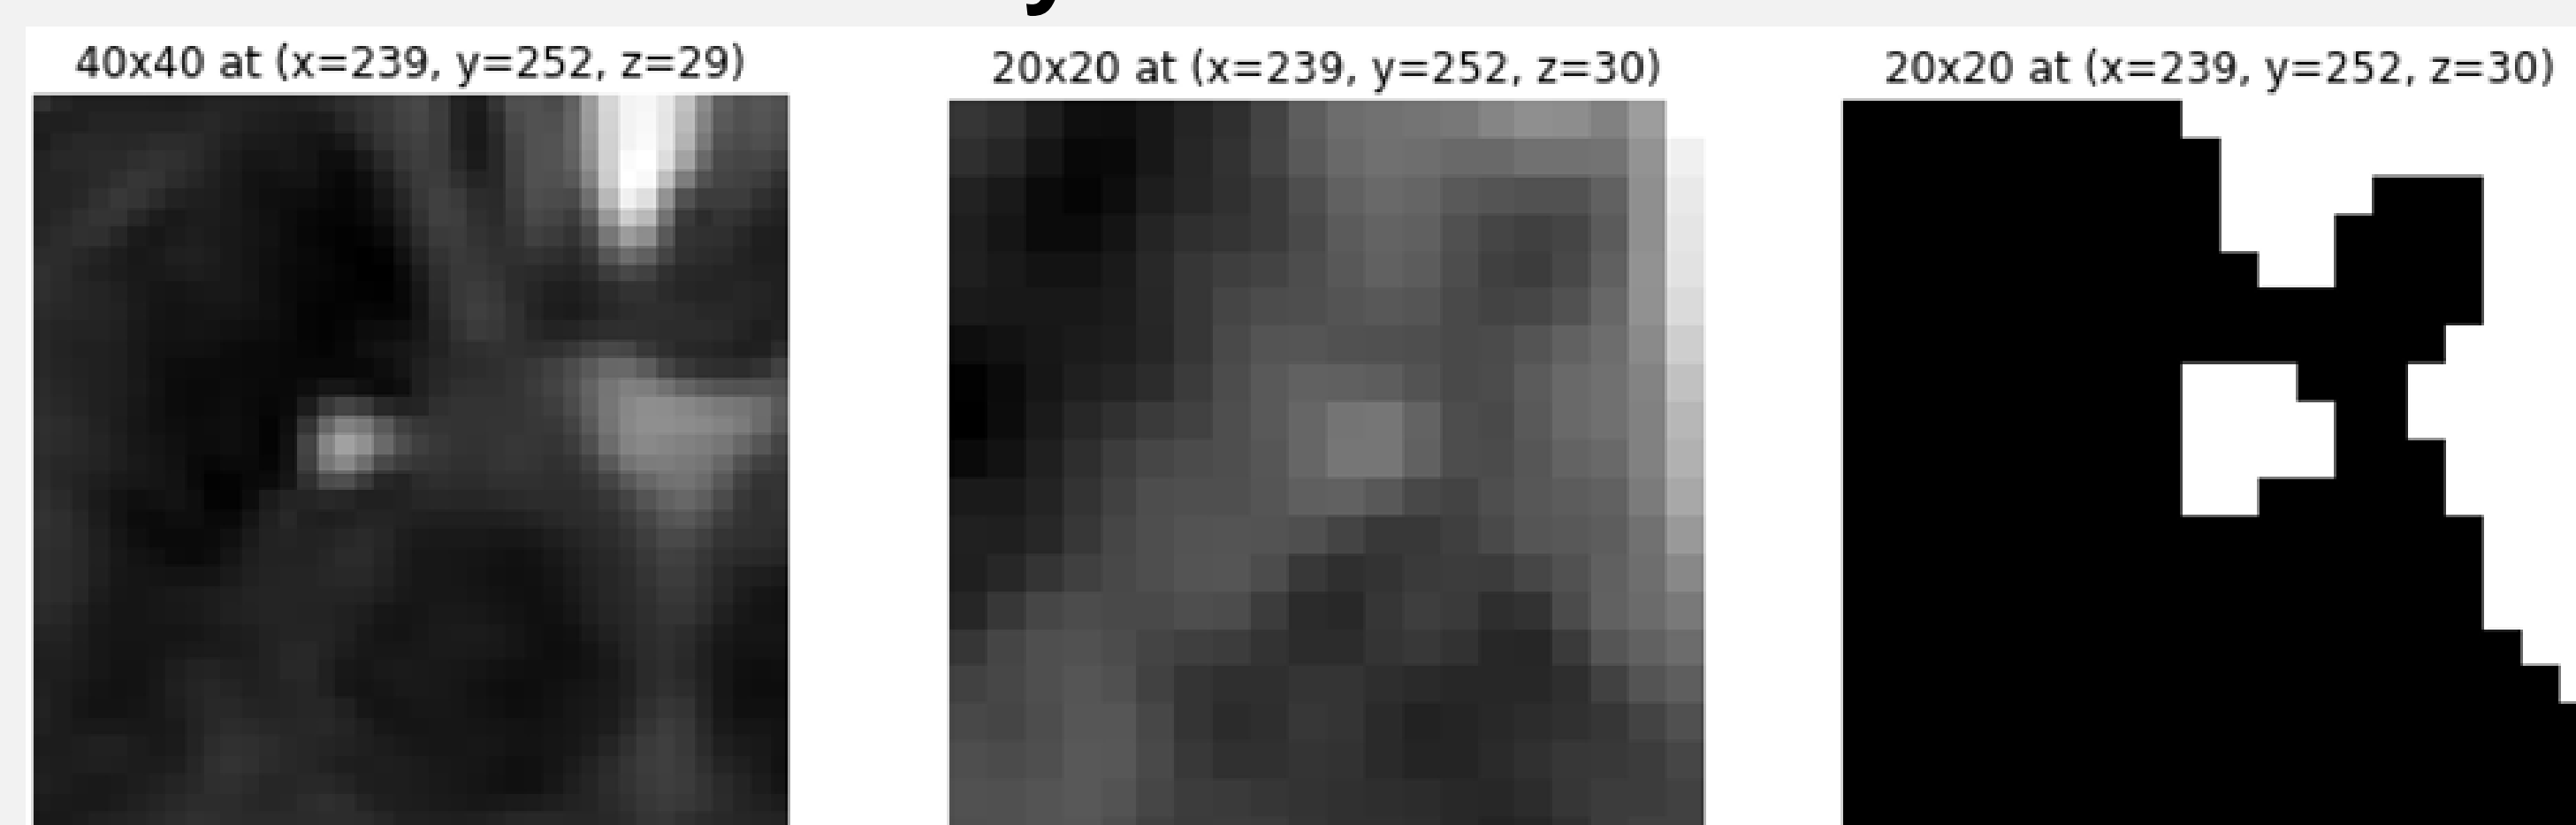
Cutout from potential cyst in P1. Left to right: original MRI at z=29 (the best cyst visibility), cutout from detection [239, 252, 30] and binary cutout from detection.
